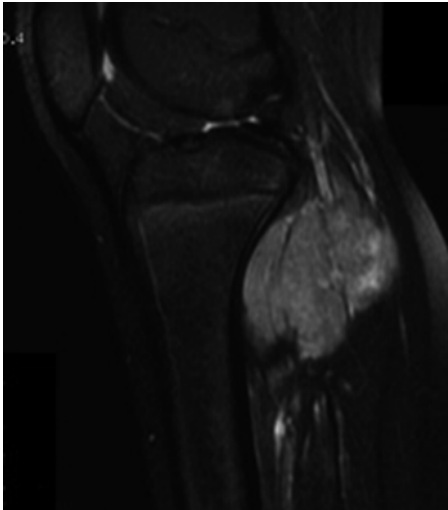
Nine-year-old girl presented with a rapidly enlarging mass in her calf. T2-weighted MRI shows the tumor located in posterior compartment of the leg. The biopsy revealed a synovial sarcoma
